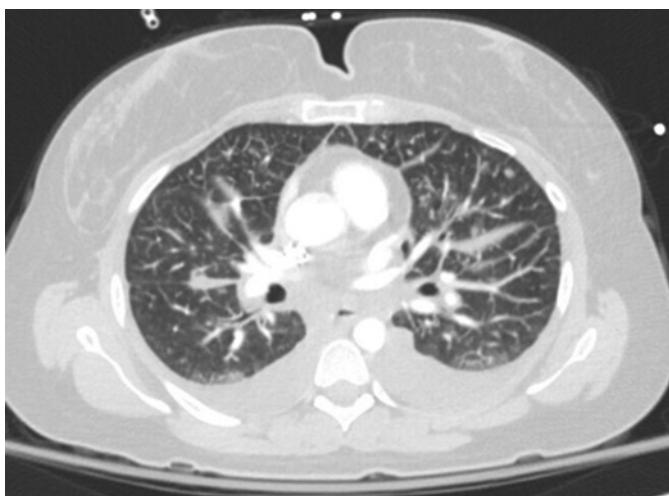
Chest computed tomography on day 0 demonstrating extensive pulmonary edema with bilateral effusions.
